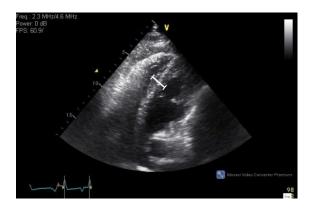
Static image form point of care ultrasound showing a markedly widened vetricular septum of about 1.8 cm (normal < 1.1 cm).
